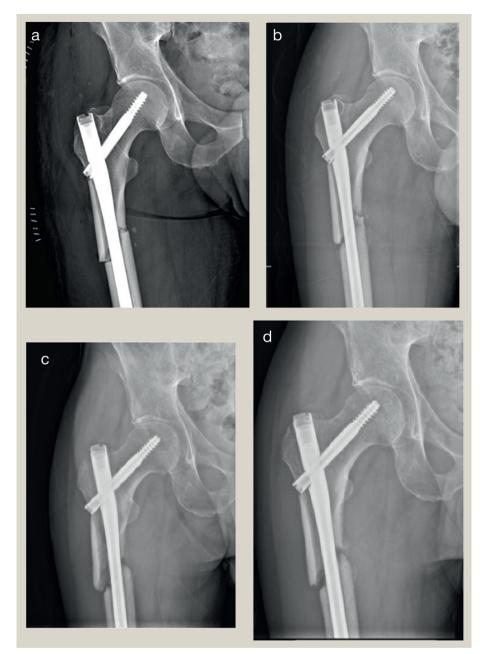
Closed right femoral fracture treated with an intramedullary nail. (a) Immediate postoperative X-ray demonstrates fracture acceptable apposition. (b) At 1 month later shows early lysis. (c) Taken at 3 months, showing further lysis and (d) at 6 months there is now lysis involving the medial cortex. This case was infected with pus in the canal on nail removal.
